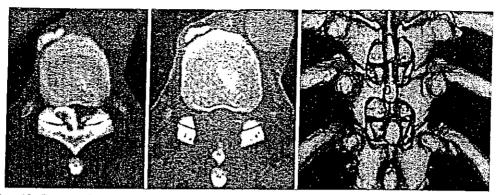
Case 10. Computerized tomography scans obtained in a man who underwent resection of an OLF at T9-11 when he was 44 years of age. Left: Preoperative axial CT scan (obtained at T-9) demonstrating the OLF. Center: Postoperative CT scan (at almost the same level) demonstrating that the OLF was removed while preserving the lateral parts of the facet joints. Right: Postoperative 3D CT scan revealing that laminotomy with medial facetectomy was achieved precisely.
